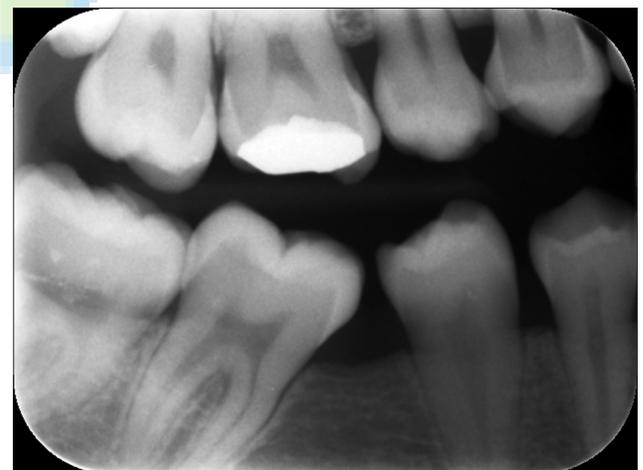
Plate surface contamination. A right bitewing image whose lower right part has radiopacities resulting from surface contamination with foreign particle
